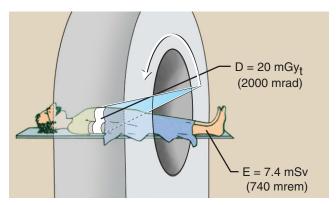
The relationship between tissue dose and effective dose during computed tomography.
